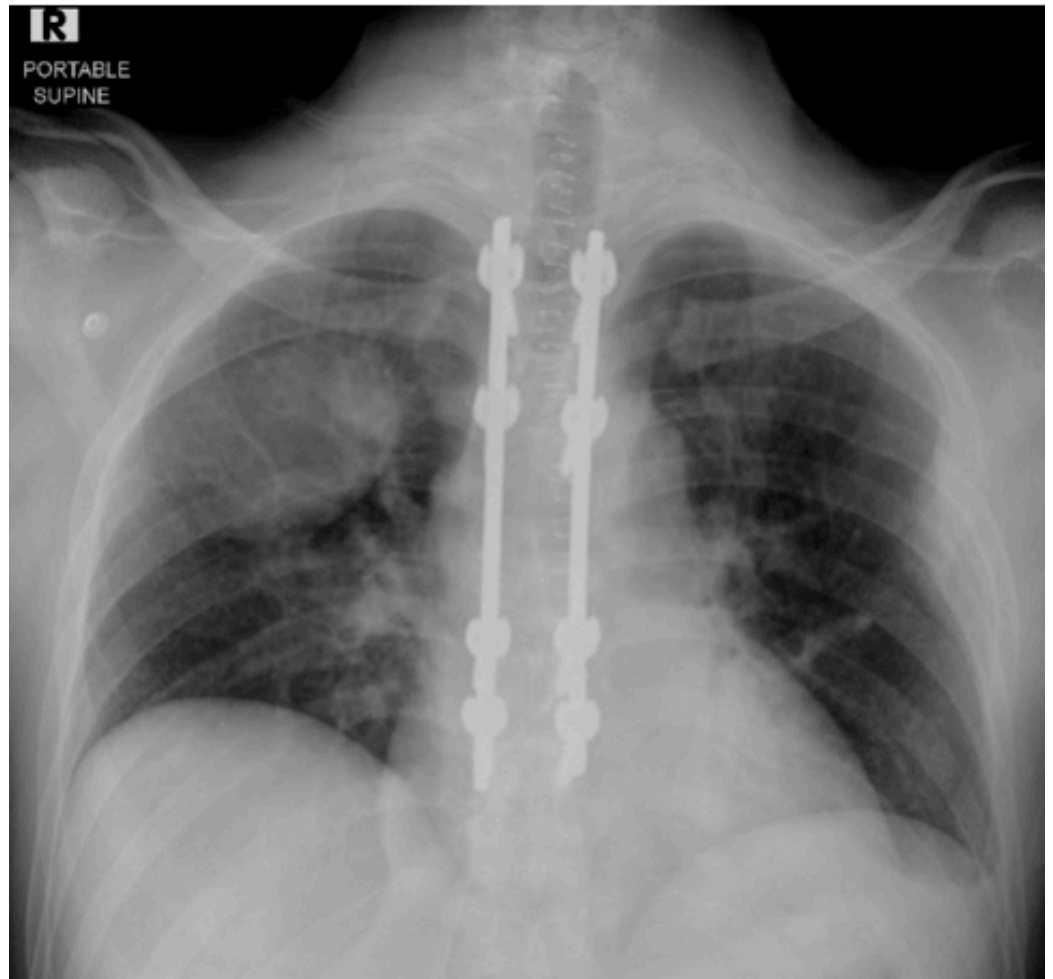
Frontal chest radiograph post spinal surgery. Thoracic spinal fixation hardware, surgical clips, and drain in situ—bilateral expansile rib lesions of variable size.
